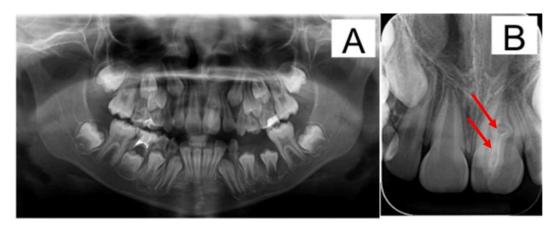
Radiographic images: A) panoramic radiograph showing patient in mixed dentition with deciduous and permanent teeth in different stages of formation; B) periapical radiograph showing Tooth 21 with large pulp chamber and abnormality similar to "one tooth inside another" image indicated by arrows.
